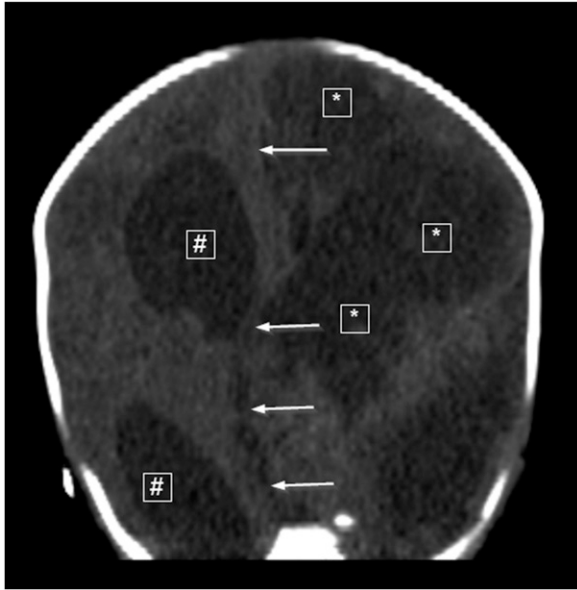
Computed tomographic scan of the head demonstrating a large fluid collection with irregular margins in the left cerebral hemisphere consistent with cerebral abscess (*). The abscess is noted to be causing significant mass effect with midline shift (arrows) causing secondary compression of the ventricular system with evidence of ventricular dilation over the right hemisphere (#).
